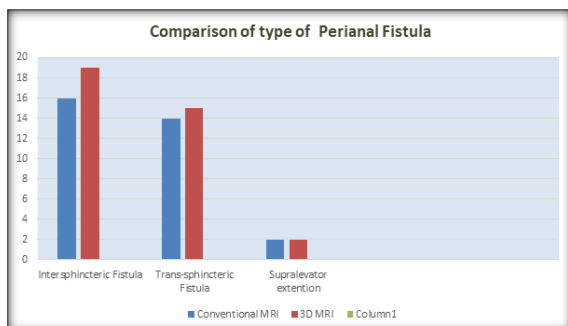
Comparison of conventional and 3D MRI in assessment of course of perianal fistula: 3 intersphincteric fistula and 1 trans-sphincteric fistula were not identified on conventional MRI and which were picked up on 3D MRI
